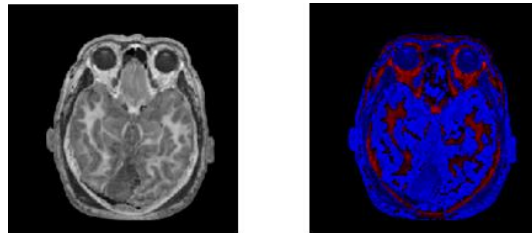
4 RGB Cube pseudocolor map of MRI image
